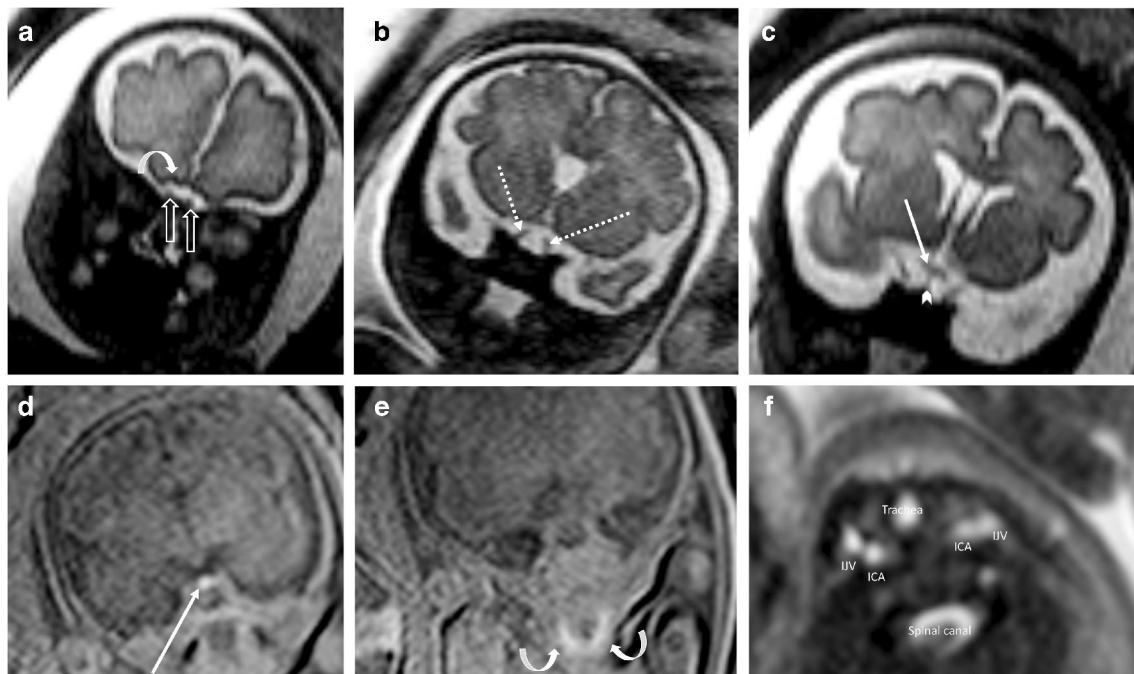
Normal central nervous system (CNS) findings at fetal MR imaging. a–c Coronal single-shot turbo spin-echo images in a 30-week fetus. The olfactory bulbs (straight arrows in a) and olfactory sulcus (curved arrow in a) are better visualized when the pericerebral fluid spaces are large. Note the optic nerve (dashed arrows in b), optic chiasma (arrow in c) and pituitary stalk (arrowhead in c). d, e Coronal
